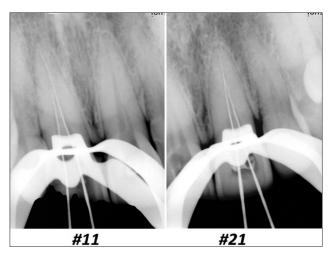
Working length X-rays of 11 and 21
